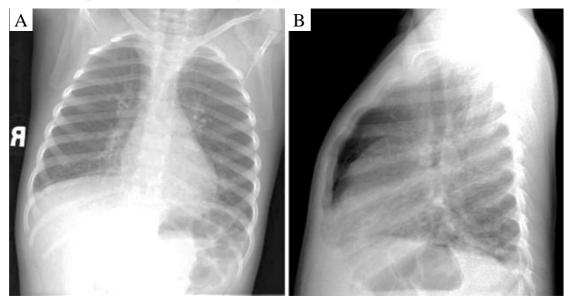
Anteroposterior (A) and lateral (B) radiographs from a child with presumptive viral pneumonia
